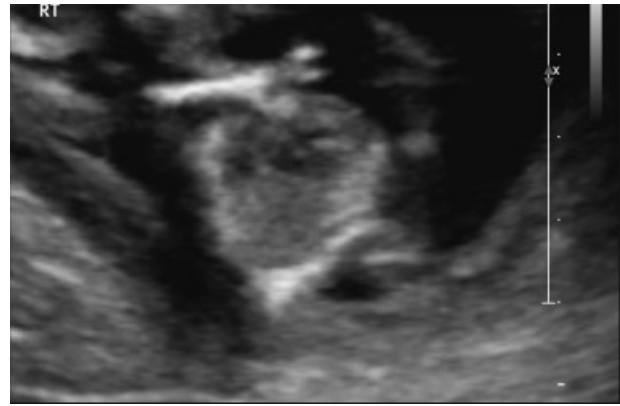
Two-dimensional ultrasound view of ectrodactyly at 15^{2/7} weeks of gestational age on follow-up ultrasonography.
